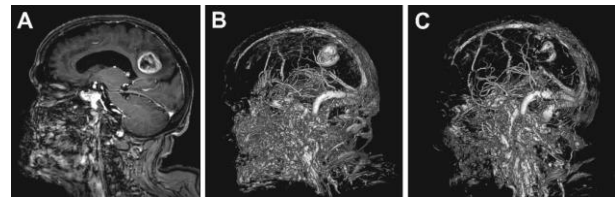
Glioblastoma case; a- Sagittal contrasted MRI, b- Relation with tumors and vascular structures is seen in 3D Angio Window Image, c- The presence of tissue in the postoperative residue in 3D angio window image.
